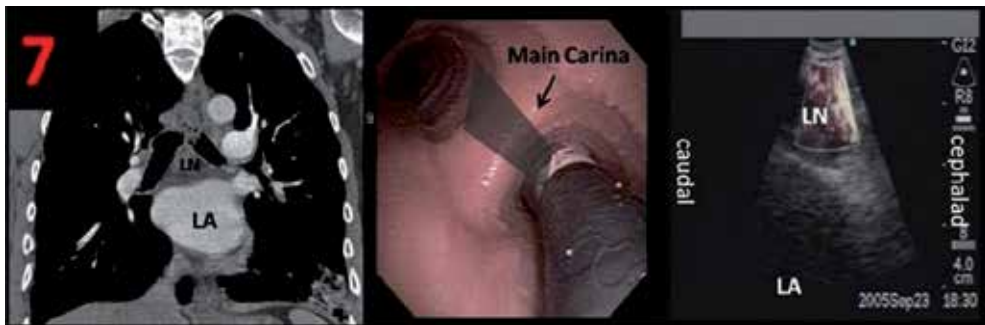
The subcarinal station shown on CT scan (left panel) can easily be visualized with both EUS (right panel) but of course also with EBUS. During EUS, the subcarinal station identifies as a round, hypoechoic sharply edged structure located in between the esophagus and the pulmonary artery. The upper rim of this artery corresponds in general with the main carina and is helpful during EUS. The main carina is visualized by means of endoscopy during EBUS. The inferior border is the roof of the lower lobe bronchus on the left and the bottom of the bronchus intermedius on the right. There are no unique ultrasound features that correspond to this definition although endoscopy during EBUS is helpful [21]. Courtesy of Septimiu Murgu, MD and Henri Colt, MD; Bronchoscopy International www.bronchoscopy.org
